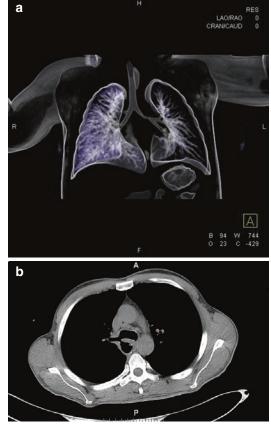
(a) Thoracic CT image shows abnormal vascular compression of the trachea. (b) Thoracic CT image shows the esophageal-right main bronchial fistula
